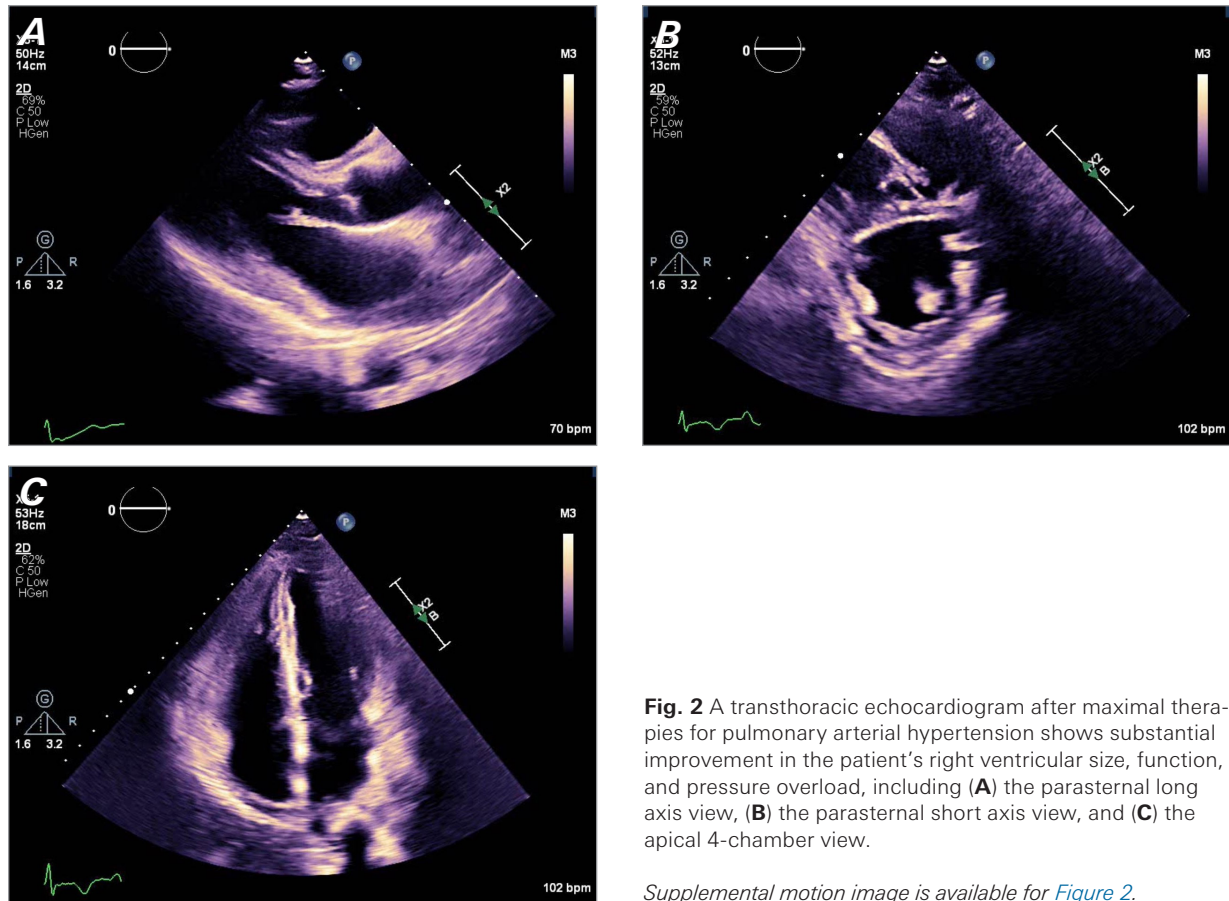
A transthoracic echocardiogram after maximal therapies for pulmonary arterial hypertension shows substantial improvement in the patient's right ventricular size, function, and pressure overload, including (A) the parasternal long axis view, (B) the parasternal short axis view, and (C) the apical 4-chamber view.
